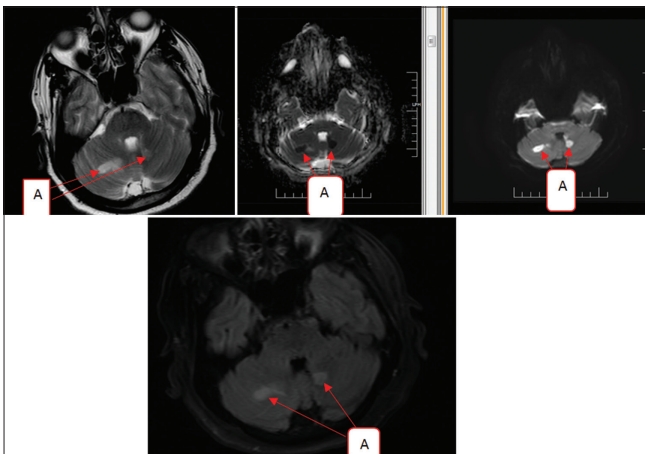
Magnetic resonance imaging brain study shows bilateral cerebellar infarct with the left superior cerebellar peduncle showing restricted diffusion and low apparent diffusion coefficient values
